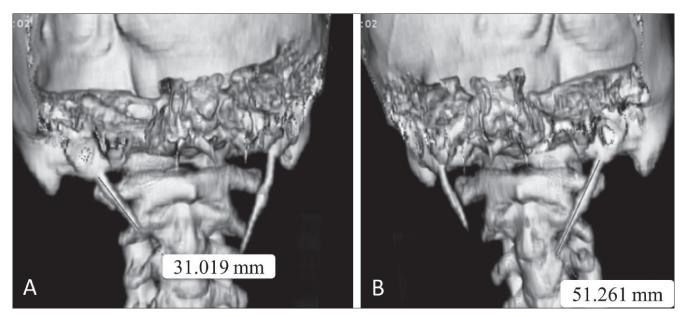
Preoperative 3D CT of Eagle's syndrome. A, B) Preoperative 3D CT. The left styloid process measured 3.1 cm, while the right was 5.1 cm.
